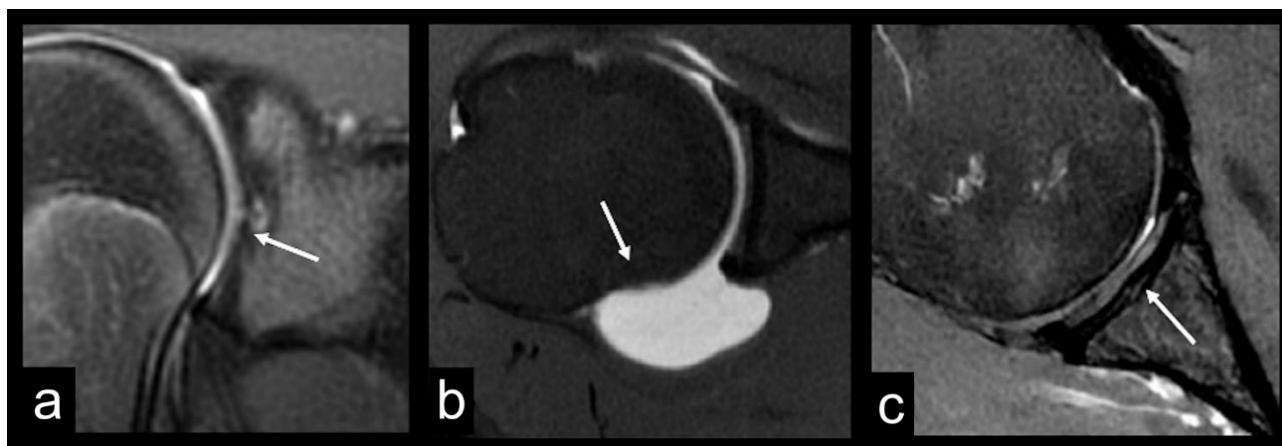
MRI findings of anatomical variants in the glenoid and humeral head. (A) Bare area of the glenoid: a normal focal articular defect located at the central and inferior aspect of the glenoid. (B) Bare area of the humeral head: a region between the posterior insertion of the joint capsule and the adjacent articular cartilage, which may mimic a Hill-Sachs impaction injury. (C) Tubercle of Assaki: a focal thickening of the subchondral bone along the central aspect of the glenoid fossa.
